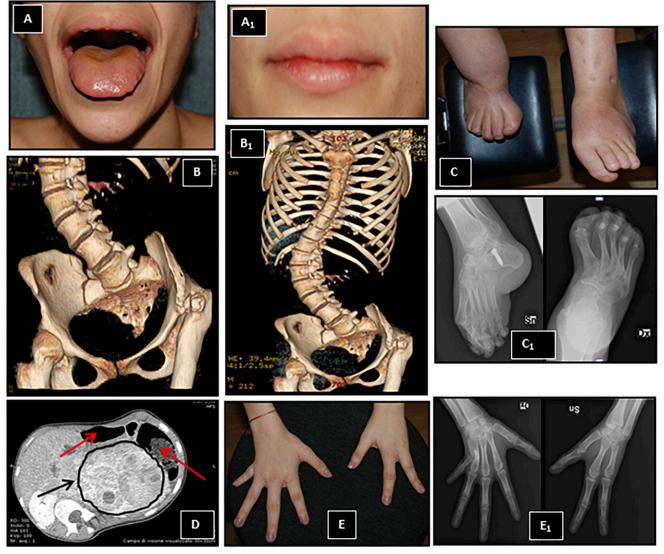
Typical physical features of the MEN 2B phenotype in the 25-year-old woman. (A) Mucosal neuromas of the tongue. (A₁) Bumpy lips. 3D CT scan reconstructions of the front view of the vertebral column and pelvis showing (B) scoliosis of t he column and (B₁) a severe hip epiphysiolysis of the left femur. (C) Congenital malformed feet already treated at the orthopedic level. (C₁) A screw implanted in the heel to improve the use of the left foot. (D) CT transversal abdominal section showing a large pheochromocytoma of the left adrenal gland (black arrow) and typical megacolon (red arrows). (E and E₁) Malformations of the hands with oligodactyly of the left hand and a shorter fifth finger of the right hand.
